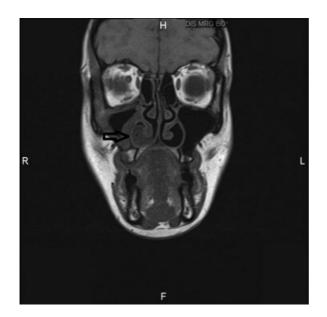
Preoperative maxillofacial magnetic resonance imaging (coronal T1-weighted). Arrow shows the mass originating from the right inferior turbinate.
